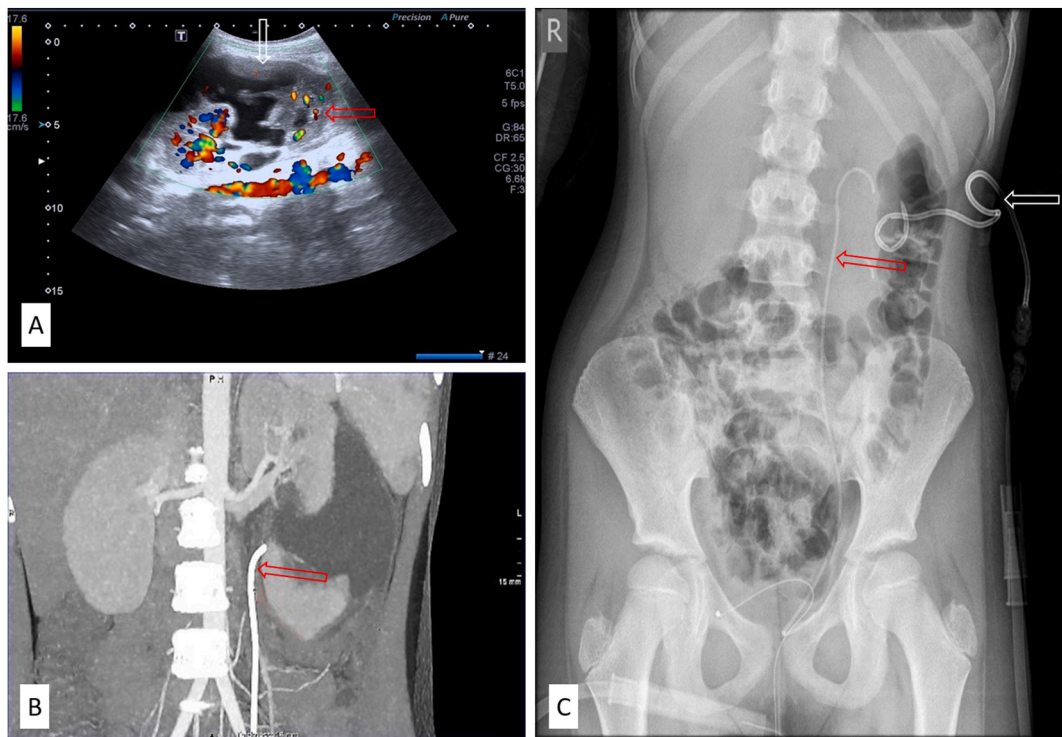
A–C: (A): Follow-up was done by color Doppler ultrasonography, revealing a perinephric collection/urinoma (white arrow) with preserved vascularization of both poles of the left kidney (red arrow); (B): CT urography was also done, and migration of the stent was observed; (C): Percutaneous drainage catheter was inserted to evacuate enlarged urinoma. The stent was reinserted. (For interpretation of the references to color in this figure legend, the reader is referred to the Web version of this article.)
